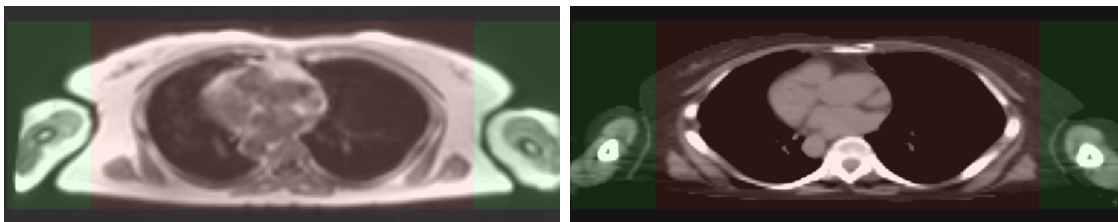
Axial slices of registered MR (left) and CT (right) images with mask overlays. The full-body rectangular mask (green) encompasses the entire patient anatomy and was used for GAN training. The thoracic cage mask (blue) focuses on regions with high registration accuracy and was used for the KRR model training, leveraging the precise alignment in this region.
